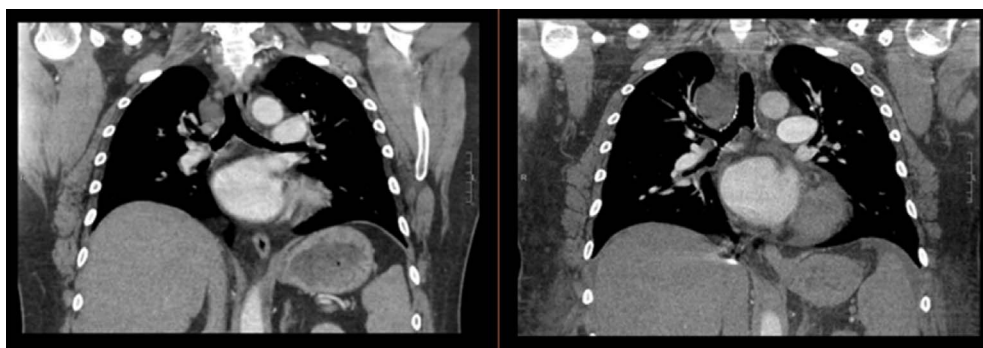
CT imaging of the paratracheal mass before (right) and after (left) aspiration using the EBUS needle.
